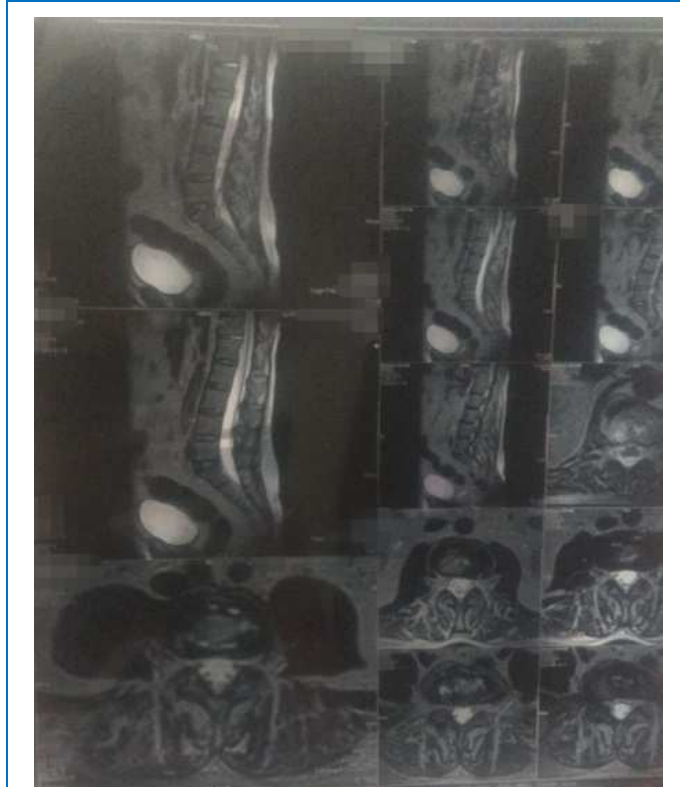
MRI - Cervical and Lumbo Sacral spine film
